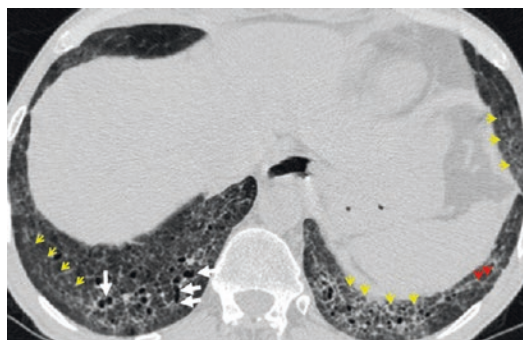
Nonspecific interstitial pneumonia in a 57-year-old male patient with diffuse systemic sclerosis. Chest computed tomography (CT) scan shows predominantly ground-glass opacities (yellow arrows), irregular reticular opacities (red arrows) with or without traction bronchiectasis (white arrows), minimal honeycomb changes, and subpleural sparing, which are some of the radiographic characteristics that differentiate nonspecific from usual interstitial pneumonia (Figure courtesy of Christos Kampolis, MD)
